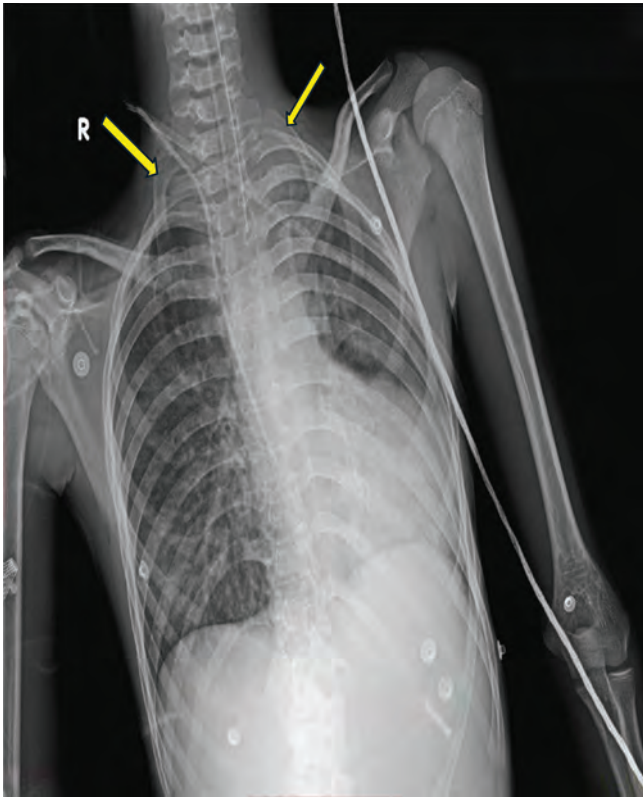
Radiograph of control showing bilateral cervical rib (yellow arrow)
